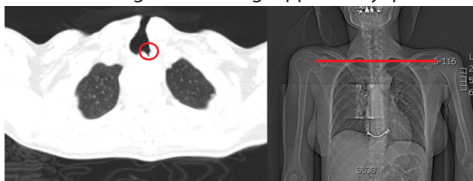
Axial noncontrast-enhanced computed tomography (CT) shows at the upper edge of the tracheostomy an diverticular extension corresponding to the tracheoesophageal fistula (TOF) (Department of Radiology, Cantonal Hospital Zenica, 2016)
